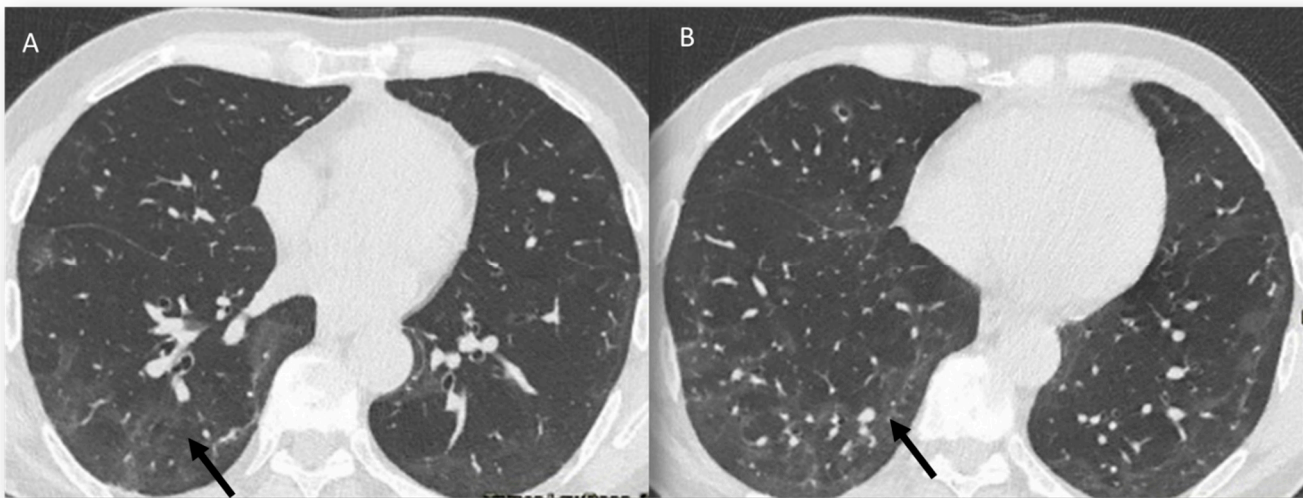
CT assessment of COVID-19 pneumonia (A,B): multifocal and bilateral distribution of ground-glass opacities (arrows).
